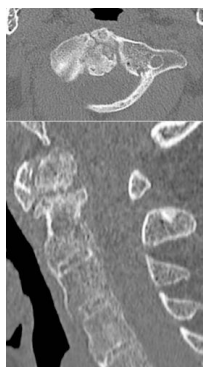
CERVICAL CT (axial (upper) and sagittal (lower)): fracture through body of C2 (odontoid) without displacement.
